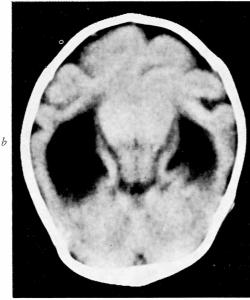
Horizontal sections of a postnatal cranial CT scan showing a) a large single ventricle with partial sagittal separation and b) midline fusion of the basal ganglia and thalami.
